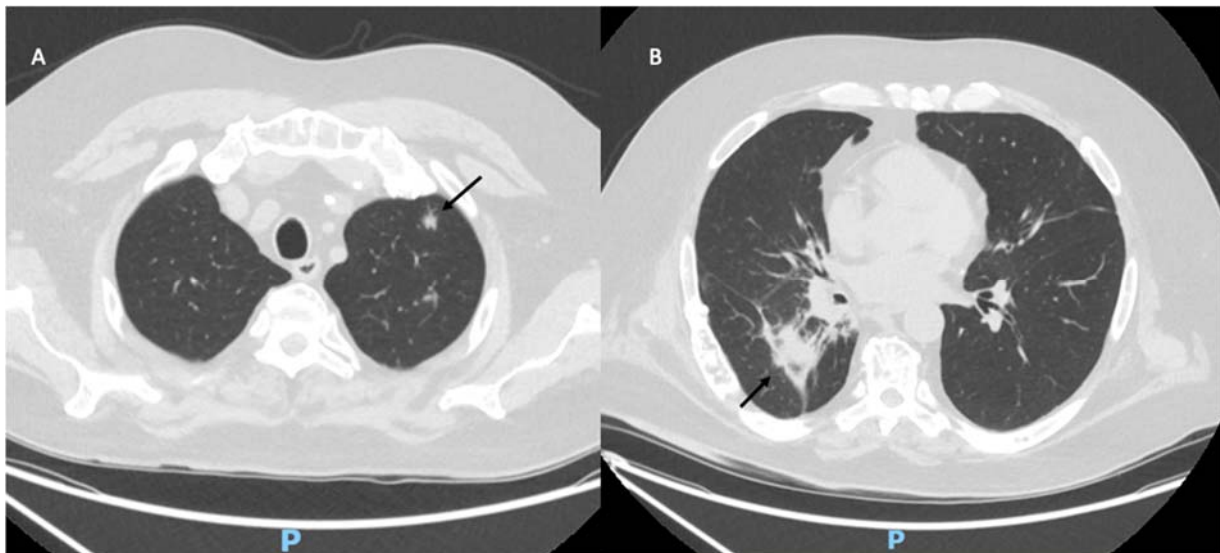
Chest CT performed on day 21 of induction therapy, axial sections, lung window. (A) Left upper lobe: the arrow indicates non-cavitated peribronchovascular consolidation, consistent with an infectious process. (B) Right lower lobe: the arrow indicates an area of consolidation with bronchiectasis. Images are displayed according to standard radiological convention (patient's left on the viewer's right). P = posterior.
